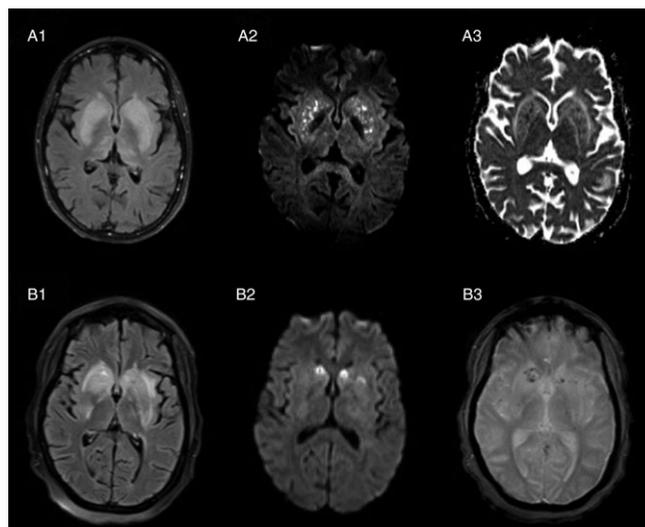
Brain MRI of striatal encephalitis in systemic lupus erythematosus. Both patients had bilateral striatal T2-hyperintensity (A1 and B1) and DWI hyperintensities (A2 and B2) with corresponding ADC hypointensities (shown for Patient A, A3), compatible with infarctions. In Patient B, GRE revealed superimposed hypointensities, compatible with petechial hemorrhages (B3).
